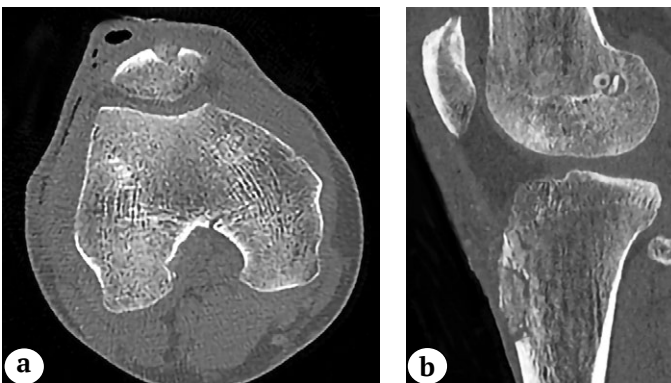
CT scans showing filled bone defects of the patella (a) and tibial tuberosity (b) on the first postoperative day
